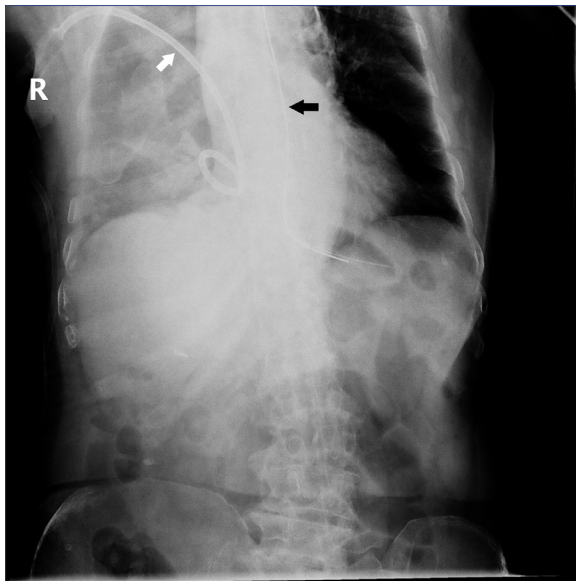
The white arrow indicating pleural drainage tube, the black arrow showing the new reinserted nasogastric tube, confirmed by bedside anteroposterior chest radiography.
